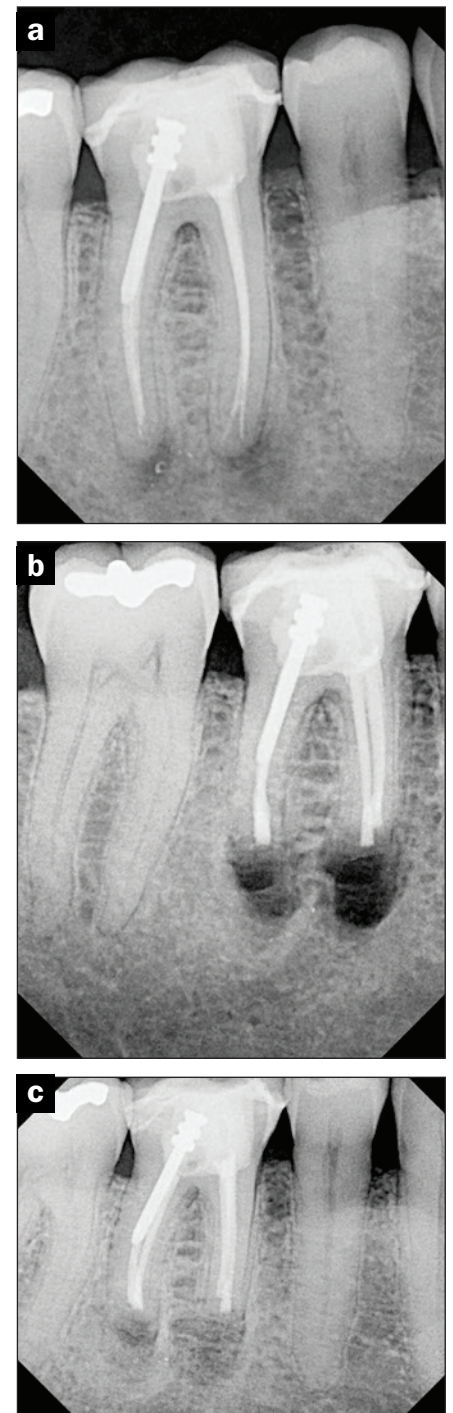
Surgical case demonstrating the use of bioceramic technology: (a) pre-op x-ray, (b) completed case, and (c) 4-month recall (incredible healing for such a short period of time). (Case courtesy of Dr. Ali Nasseh.)
